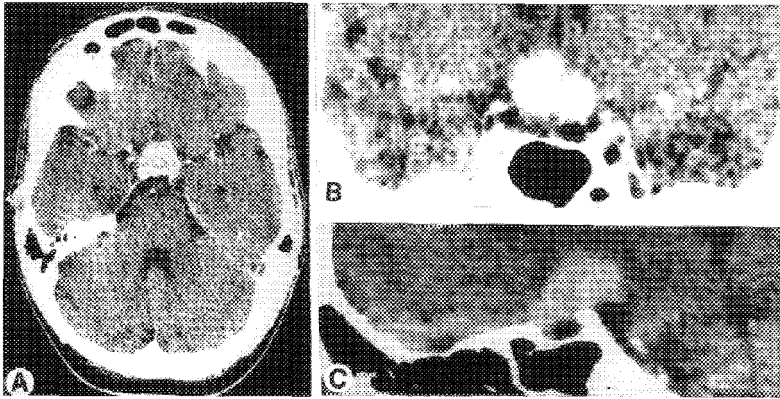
Preoperative axial (A) contrast-enhanced CT scan with coronal (B) and sagittal (C) reconstruction demonstrating a large homogeneously enhancing suprasellar tumour.
